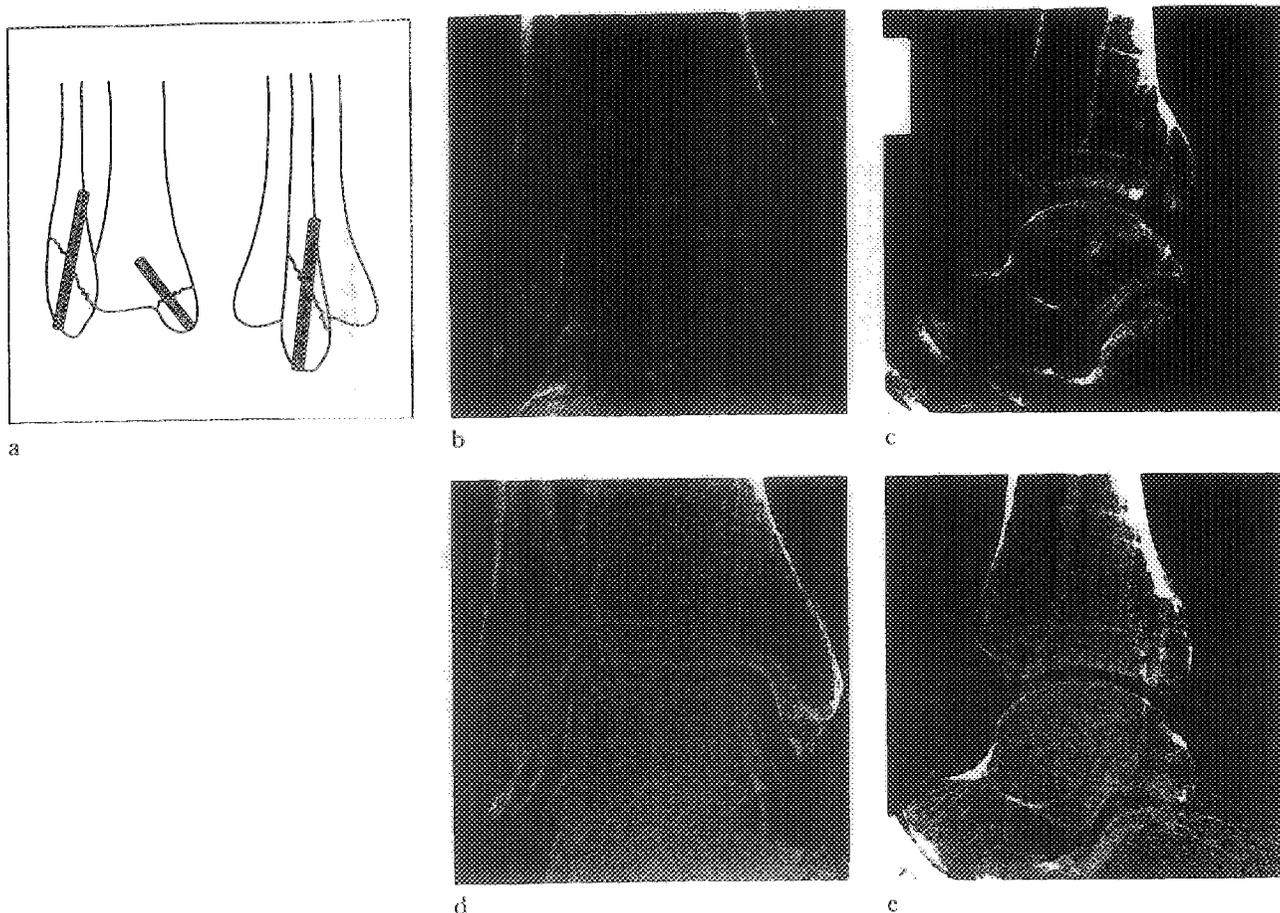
Fixation of bimalleolar fracture of the ankle (a). Radiograph of a displaced bimalleolar fracture seen in anteroposterior and in lateral view on admission (b-c) and as healed one year after fixation using one 4.5 by 70 mm BIOFIX®-rod on the lateral side and one 3.2 by 50 mm rod on the medial side (d-e).
